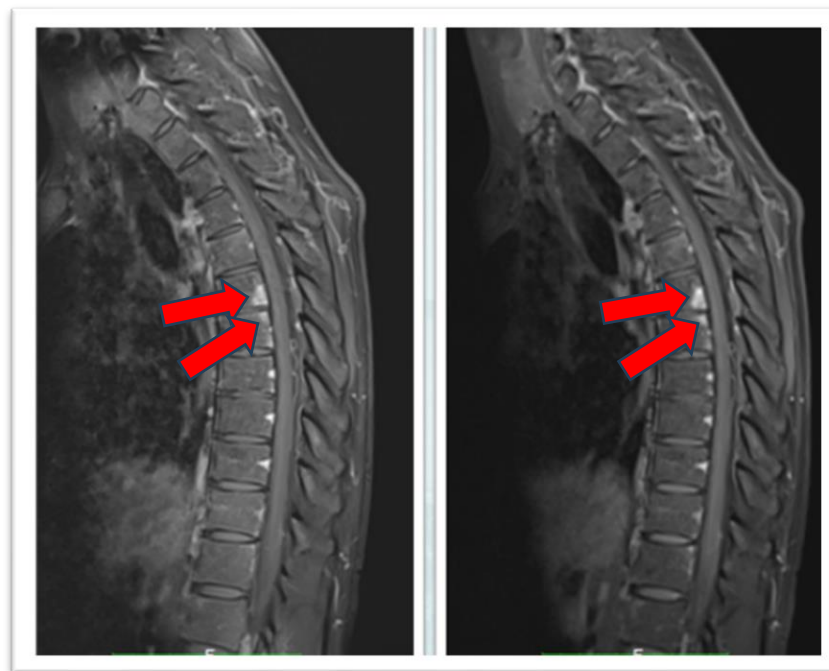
Sagittal MRI with contrast-enhanced (CE) FAT SAT sequences: confirmation of areas of altered signal intensity (arrows).
